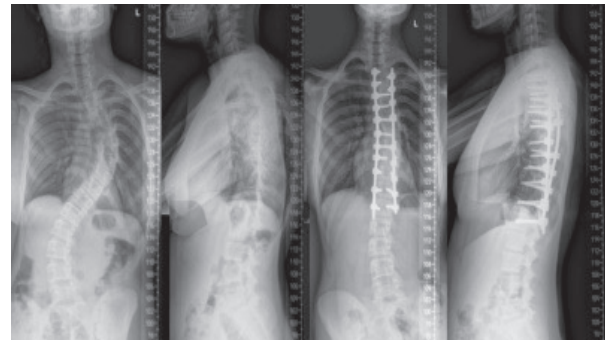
Posteroanterior and Lateral Radiographs of a 13-Year-Old Girl with a Primary Thoracic Curve before and after Surgery Treated with Posterior Fusion
